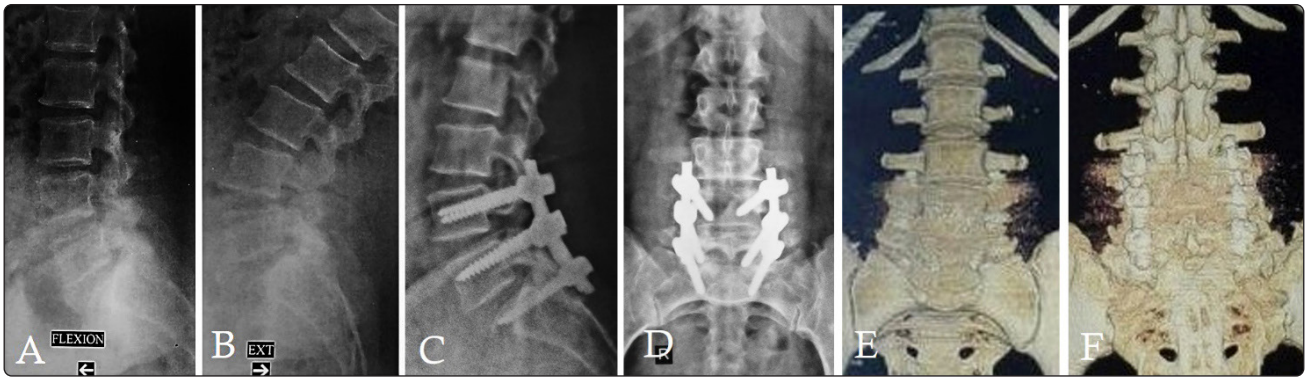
A 48-year-old housewife lateral radiographs (A) in flexion and (B) extension views showing double level first-degree degenerative spondylolisthesis at L4-L5 and L5-S1 levels, postoperative (C) lateral and (D) anteroposterior radiographs after PLF, 3D CT sacn (E) anterior view and (F) posterior view showing good PLF with local bone graft.
